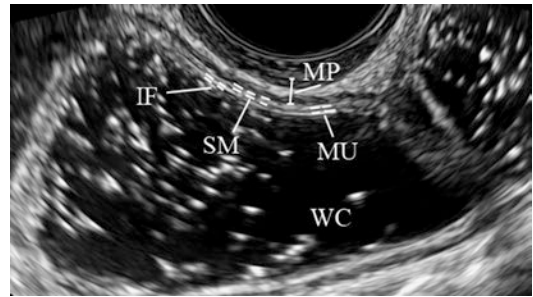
Rectal water contrast transvaginal ultrasonographic image showing normal rectal wall. The various layers can be recognized: muscularis propria (MP), submucosa (SM), and mucosa (MU). The interface (IF) between the lumen and the mucosal layer is hyperechoic. The rectum is dilated by saline solution (WC)
